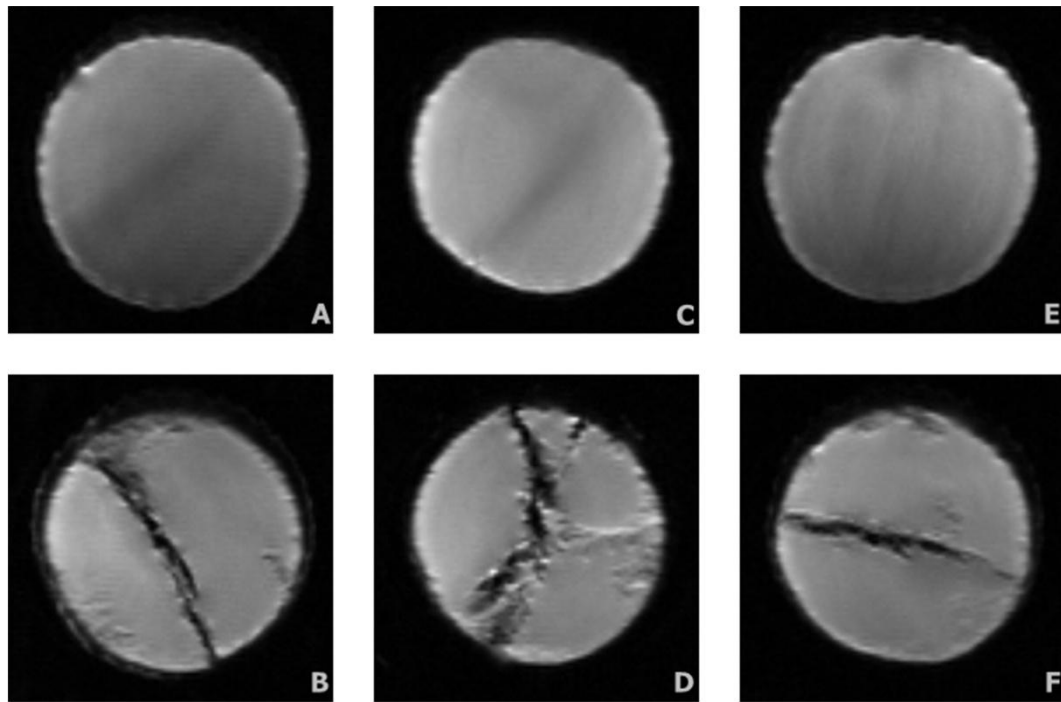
Representative T_1 weighted coronal magnetic resonance images (MRI) of the untreated (A: 4 min, B: 16 min fried), pre-dried (C: 4 min, D: 16 min fried) and pre-coated (E: 4 min, F: 16 min fried) potatoes fried in sunflower oil at 180°C .
